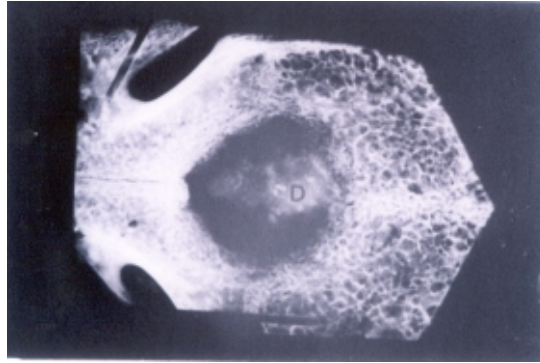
At 3 months postoperatively, radiographs only revealed sparse radiopaque areas within the control implant site. D: Calvarial defect.
